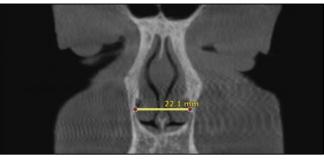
"N" parameter: CBCT image in the coronal plane.
